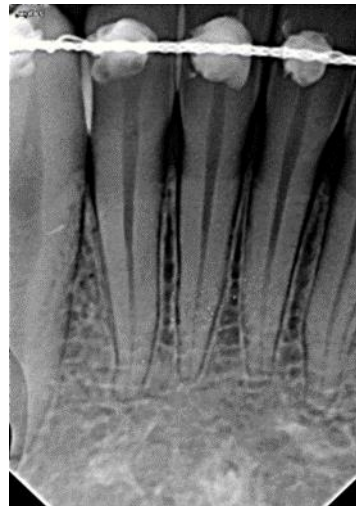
Radiograph after splinting.
